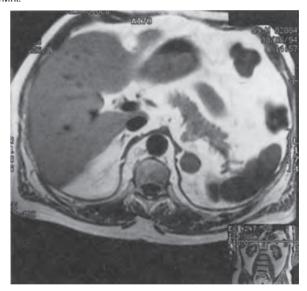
MRI scan of a patient with Cushing syndrome due to an adenoma in the left adrenal gland.
